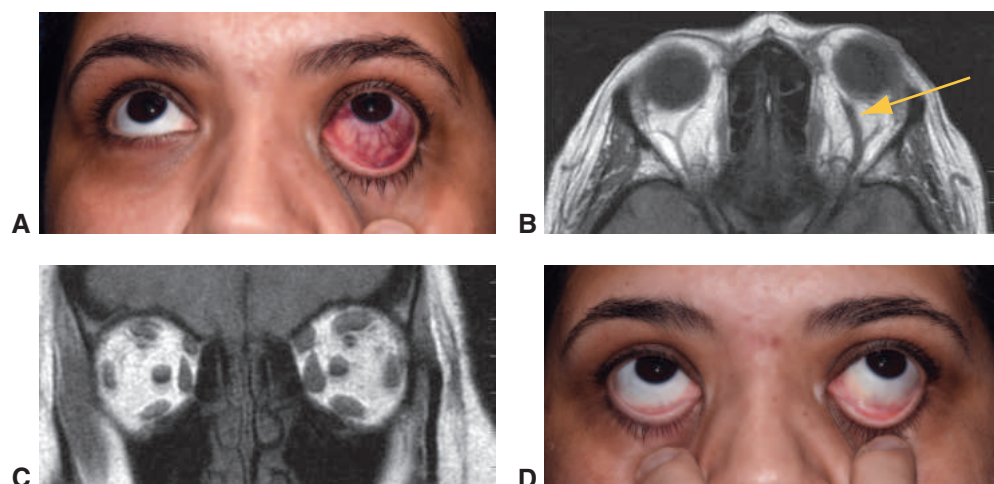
Carotid-cavernous fistula. A, Carotid-cavernous fistula presenting with left proptosis and arterialization of the conjunctival and episcleral vessels. B, T1-weighted axial MRI shows an enlarged left superior ophthalmic vein (*arrow*). C, T1-weighted coronal MRI shows diffuse enlargement of the superior oblique and all 4 rectus muscles in the left orbit. D, External photograph after endovascular closure of the carotid-cavernous fistula. (Courtesy of Bobby S. Korn, MD, PhD.)
